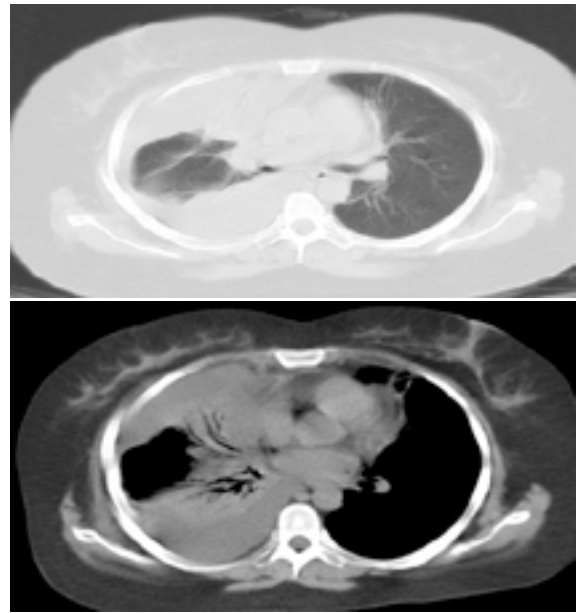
Computed tomography scan of patient's thorax, revealing pleural effusion, consolidation and air bronchogram.
